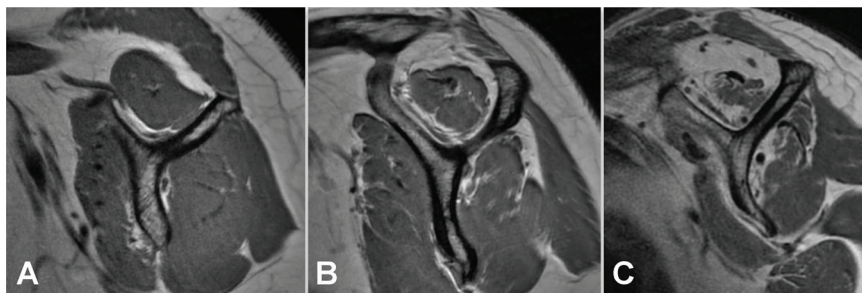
Sagittal oblique proton density-weighted magnetic resonance imaging sequence showing Goutallier grading of supraspinatus fatty infiltration. (A) No fatty infiltration. (B) Fatty streaks. (C) Substantial fatty infiltration (grade ≥ 2).
